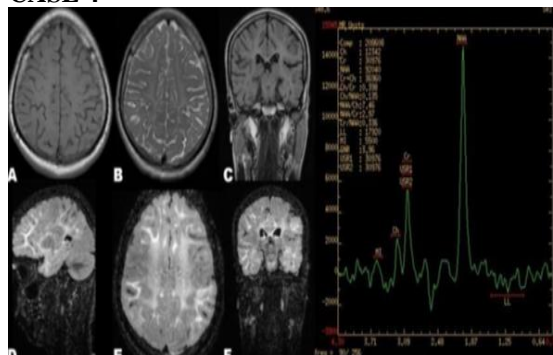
A,B,C,D,E,F– Axial T1,T2,Cornal T1, Sag, Axial, and Coronal FLAIR images showing diffuse increase in signal intensity in the bilateral cerebral white matter on T2 and FLAIR images including subcortical U fibers also. Adjacent MRS image showing NAA peak in the above-mentioned white matter which is suggestive of Canavan's Disease.
